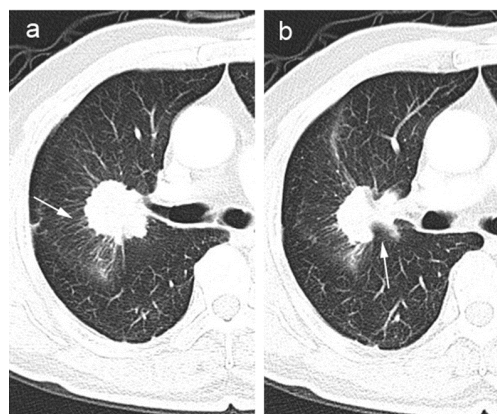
CT characteristics of a 73-year-old male patient with moderately differentiated adenocarcinoma of the right upper lobe. (a) CT plain scan showed that the lesion showed solid density and was about 42.3×37.1 mm in size. The margin was irregular, and the shallow lobulation sign, spicule sign (arrow) and pleural thickening could be seen in the lesion. (b) Deep lobulation can be seen around lesion margin (arrow).
